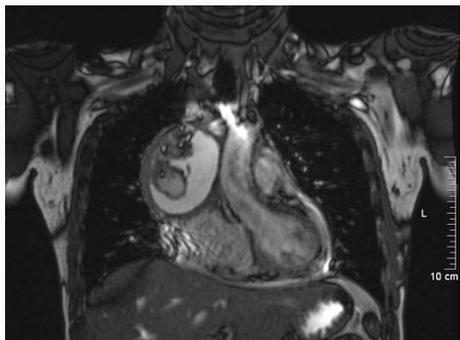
MRI image showing tumor with solid and cystic components in a T2 TRUFI sequence.
